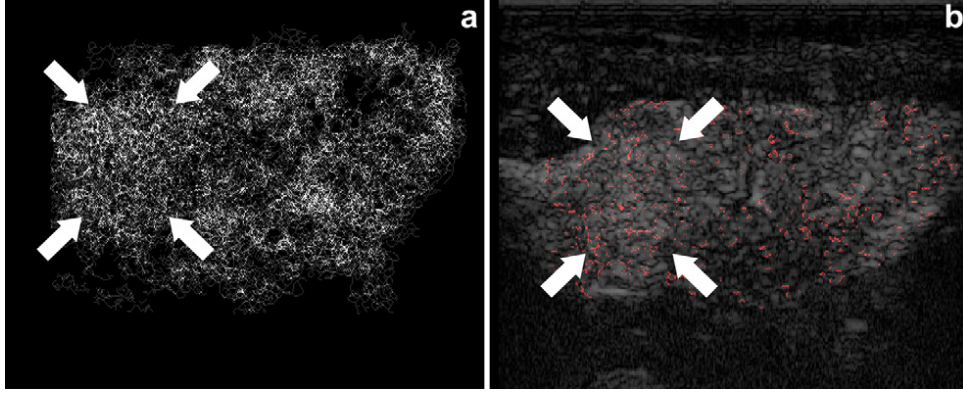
(a) Maximum intensity projection (MIP) of the 3-D skeleton. (b) Contrast-enhanced ultrasound imaging (CEUS) image of a papillary carcinoma (background) with corresponding skeleton overlaid in red (for a single slice). The white arrows indicate the nodule position. The lesion shows increased vascularity with respect to healthy thyroid tissue.
